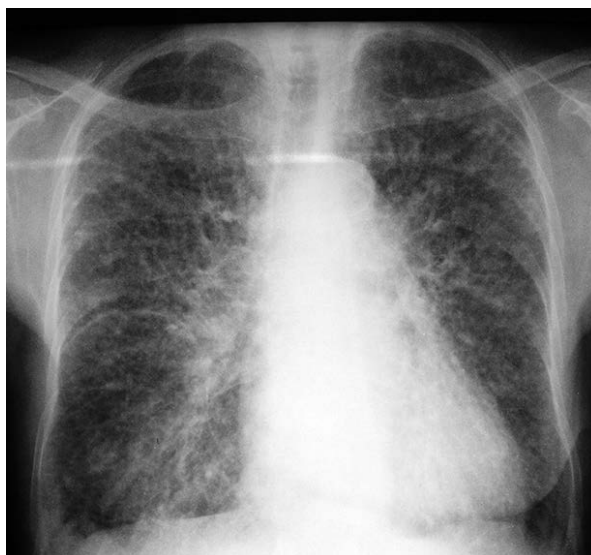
Chest X-ray showing diffuse reticulo-nodular lesions in the lungs
